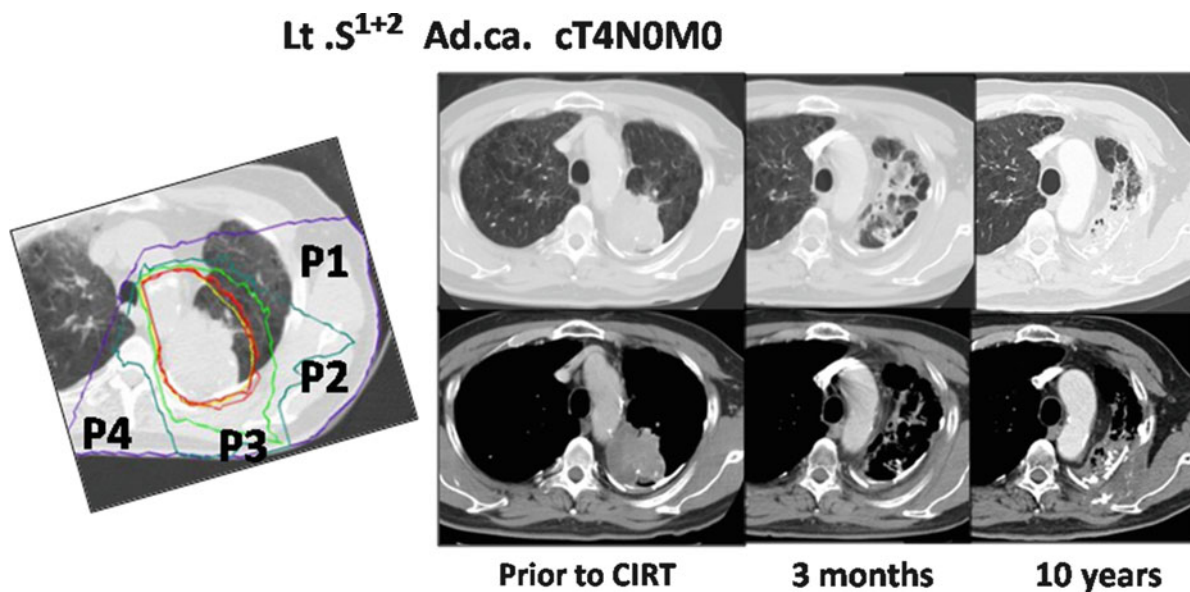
The planning CT showing the four-portal irradiation. The irradiation times for each port were P1:P2:P3:P4=4:4:5:3. The CT images taken pretreatment and 3 months and 10 years after therapy are shown
